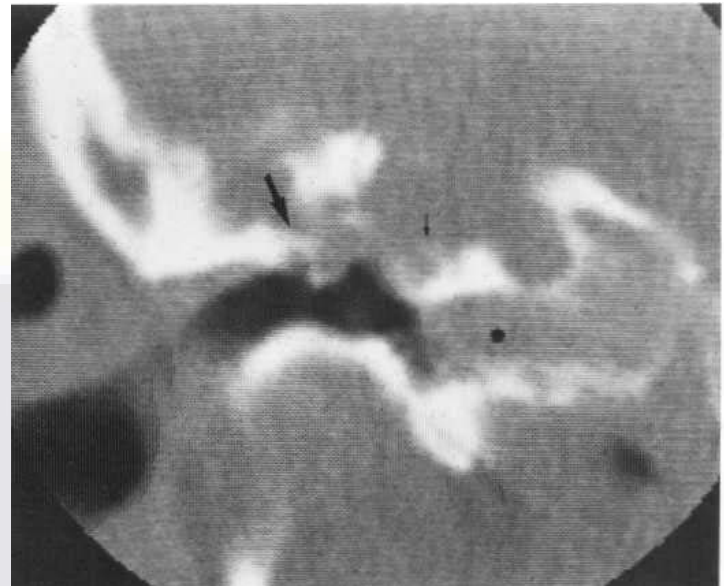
Coronal CT section showing an attic cholesteatoma which has pushed the malleus (large arrow) against the lateral attic wall, but also eroded around the labyrinth and into the top of the cochlea. The exposed central spiral of the cochlea is shown. The asterisk marks the carotid canal.
